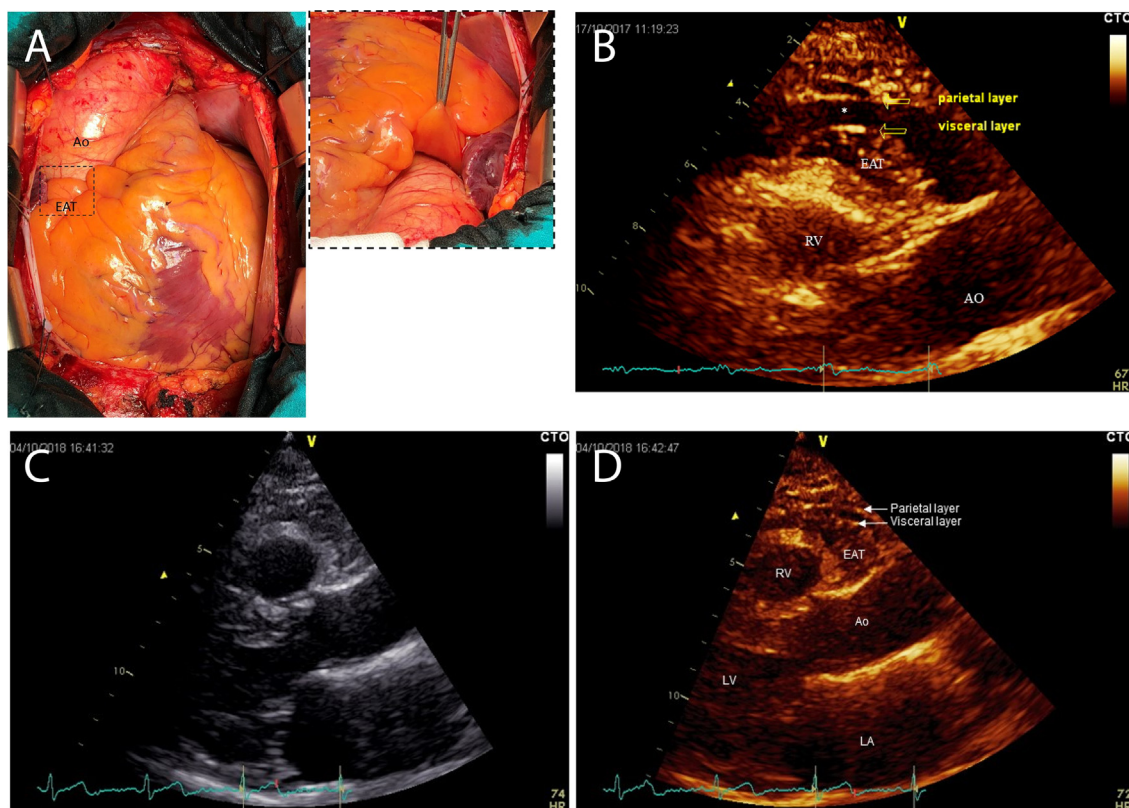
A) Epicardial adipose tissue (EAT) surgical exposure after opening the pericardium. EAT is the fat accumulation between the visceral layer of the pericardium and the myocardium. In the box, the EAT accumulation at the Rindfleisch fold. The right panel clarifies that EAT at this site is adherent to the right ventricle and not to the ascending aorta; B) EAT visualized in parasternal longaxis view at the level of the Rindfleisch fold, between the right ventricle and the ascending aorta. The presence of pericardial effusion allows to clearly distinguish the parietal pericardial layer from the visceral pericardial layer which covers the EAT; C) Standard parasternal long-axis view at end systole. D) Same view of the same patient in figure C. In order to improve EAT visualization, the angle has been modified, the focus adjusted, and the ultrasound beam frequency slightly increased. After these technical adjustments, both parietal and visceral pericardial layers can be clearly visualized, and EAT directly measured. AO, Ascending Aorta; EAT, Epicardial adipose tissue; LA, Left atrium; LV, left ventricle; RV, right ventricle.
